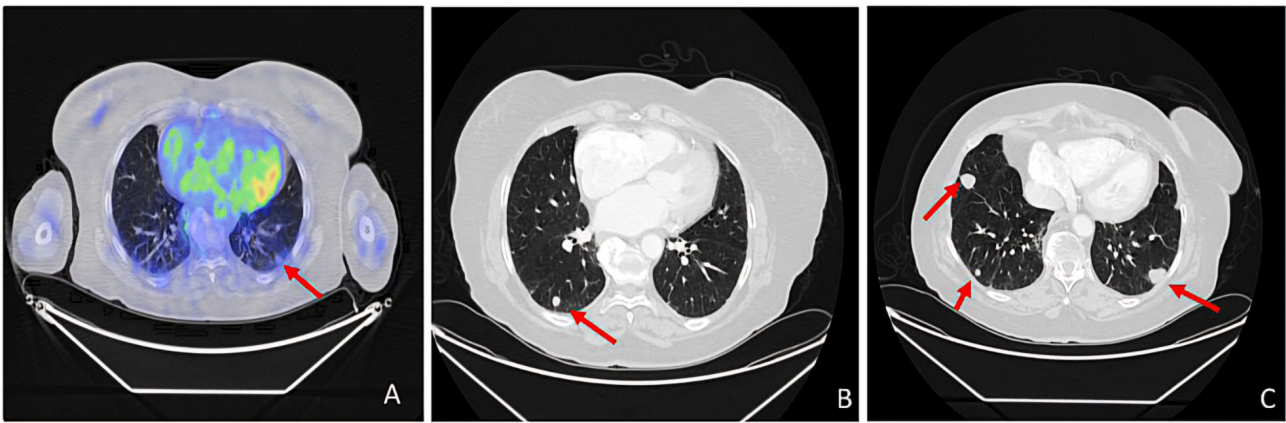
Multimodal imaging assessment with 18F-Fluorodeoxyglucose (FDG) positron emission tomography (PET) and CT. (A) 18F-FDG-PET scan showing no increased FDG uptake in the lesion located in the lower lobe of the left lung, as indicated by the red arrow. (B,C) Progressive lung disease detected on total body CT scan. The red arrows indicate the progression of the pulmonary nodule in the left lung lobe, as well as the appearance of new pulmonary nodules.
